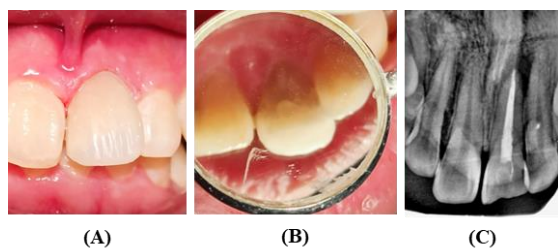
One week control. Labial (A), Palatal (B), Radiographic examination (C)
